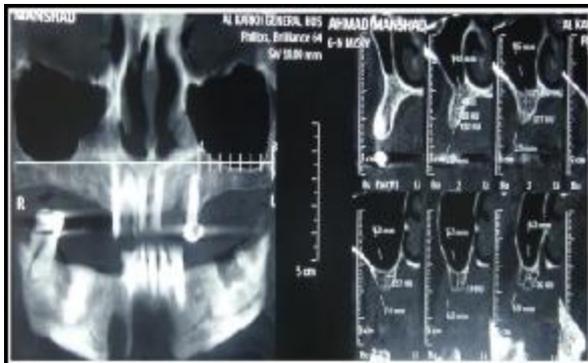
Pre-Operative Medical CT Scan Measurements Show the Height and Width of the Planned Implant Site.
